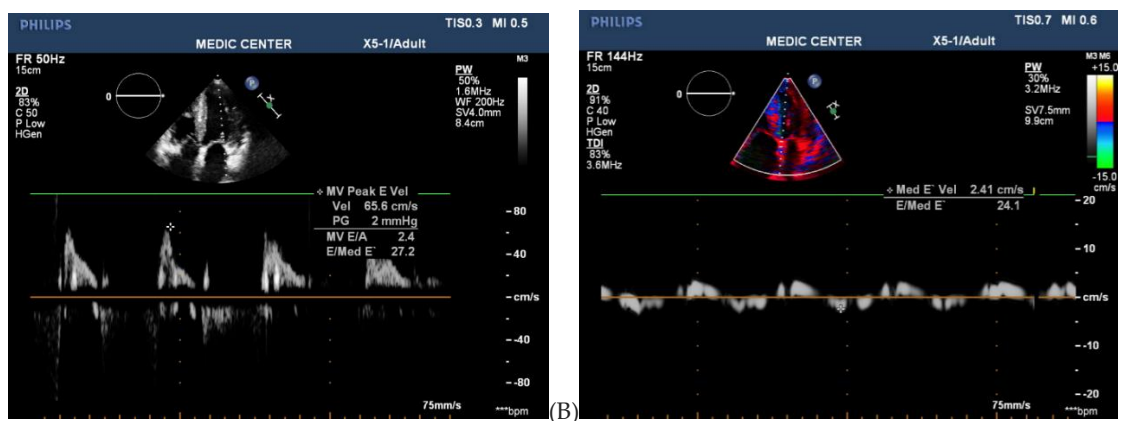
A: Pulse Doppler of mitral flow visualized a marked increased E/A ratio=2.4. B: TDI visualized the restrictive type or diastolic dysfunction of grade III: E/e'med=24.
